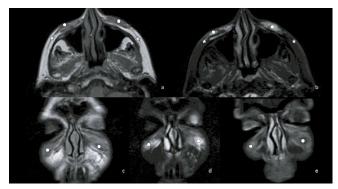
Craniofacial MRI of the patient. a) Axial T1; b) Axial T2 Fat-Sat; c) Coronal T1; d) Coronal T2 Fat-Sat; e) Coronal T1 Fat-sat with gadolinium. Circle: presence of filler material in both zygomatic/malar areas of subcutaneous localization. Star: presence of filler material above the musculoaponeurotic system (SMAS).
